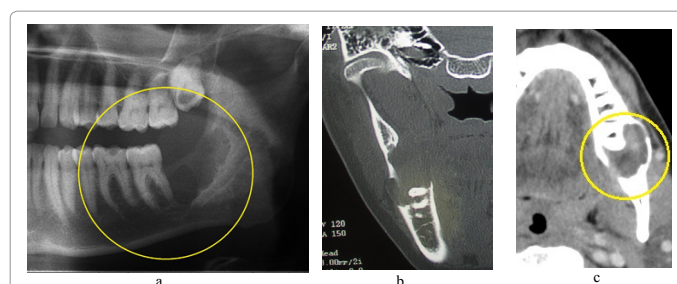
Cropped a. panoramic, b. CT bone window and c. CECT shows a well defined unilocular radiolucency with sclerotic border (straight arrows) in the left mandible. The buccal cortex exhibits considerable cystic expansion and perforation (curved arrows).
